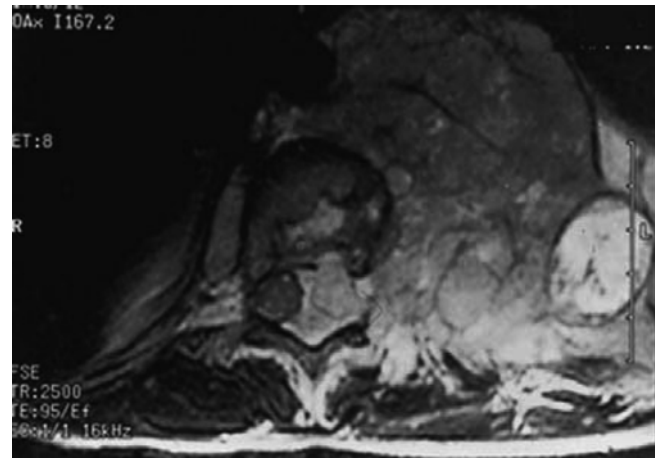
Axial T2 weighted MRI demonstrates a displaced spinal cord with tumor extension through the neuroforamina. The aorta is also encased
